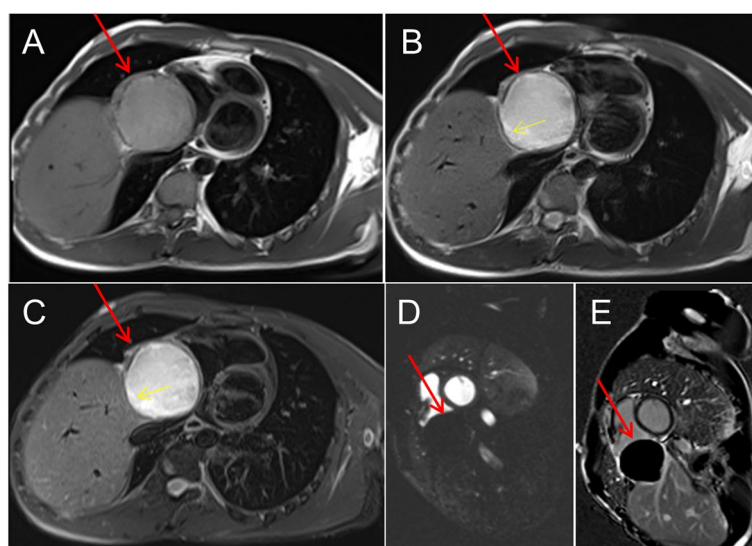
CMR Imaging findings. A-B A cystic space-occupying lesion on the right outer side of the right atrium, with slightly low signal on T1WI and high signal on T2WI and multiple small vesicles at the edge of the lesion (red arrow). C T2-weighted-turbo inversion recovery magnitude (red arrow). The yellow arrow indicates small vesicles. D Early first-pass perfusion showed no signs of perfusion within the lesion (red arrow). E Late gadolinium-enhanced showed peripheral enhancement of the lesion with no evidence of internal enhancement (red arrow)
